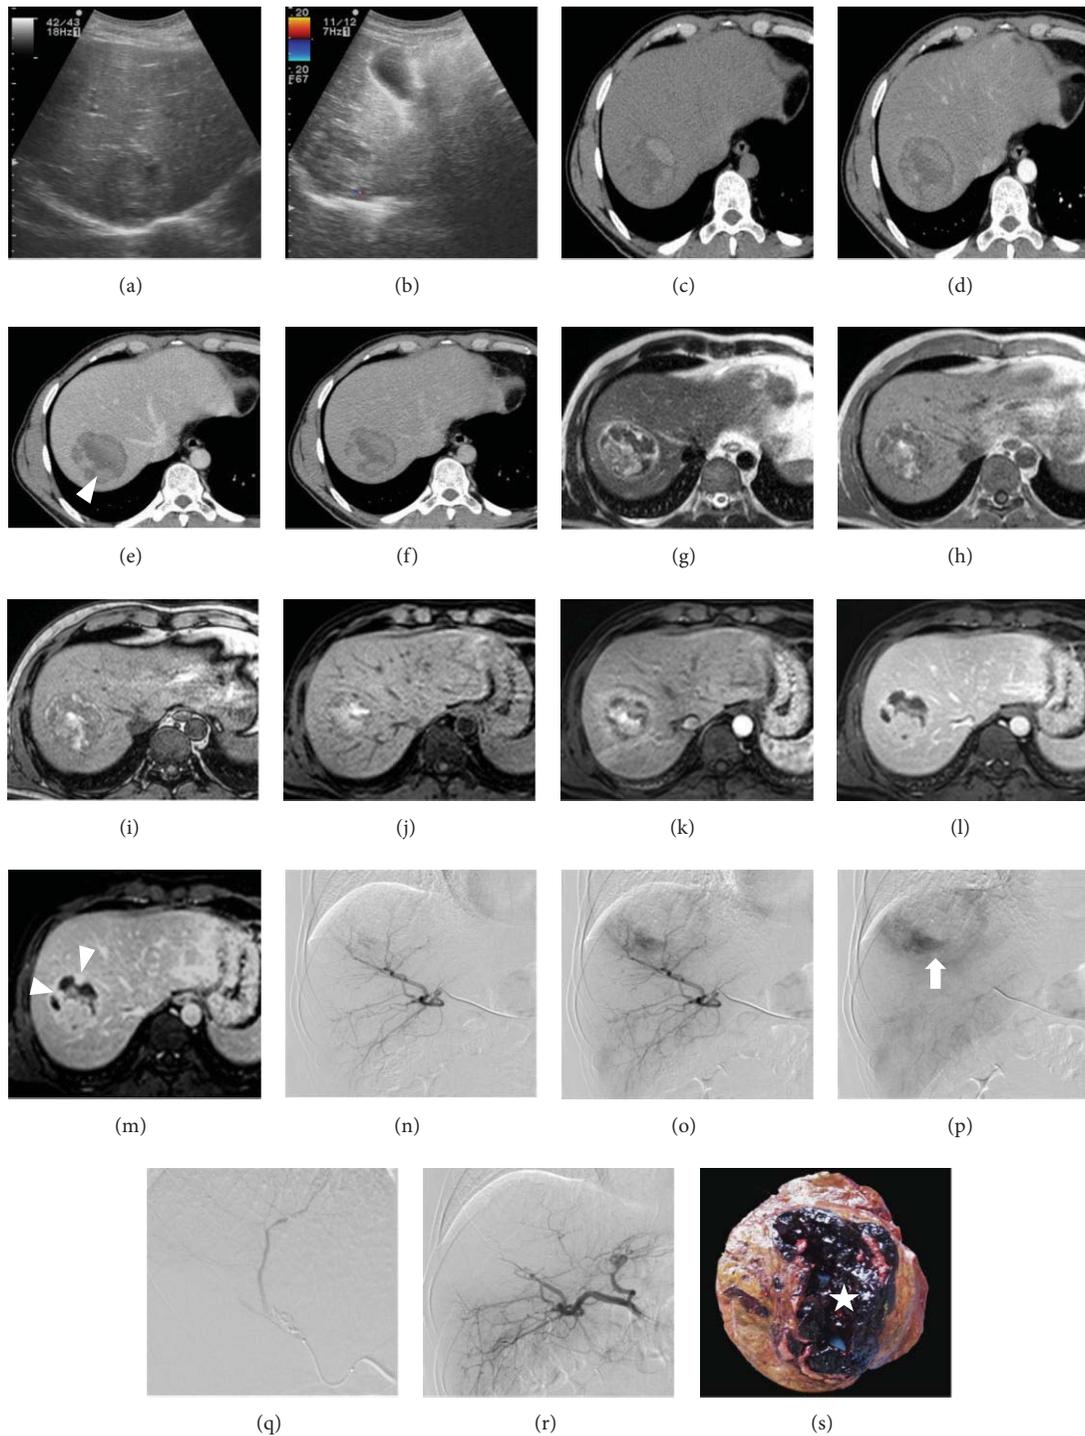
Bleeding adenoma in young man with sudden and acute upper abdominal pain. (a-b) Ultrasound, B-mode (a) and color-Doppler (b) imaging show heterogeneous lesion without significant vascularization. (c-f) CT confirms heterogeneous hyperdense bleeding mass with persistent vascularized tissue in the lower portion of the lesion (arrowheads). (g) Axial T2w image shows mixed heterogenous bleeding capsulated mass (arrows) in S VIII. (h-i) T1w in- and out-phased images confirm intralesional hemorrhage. (j-m) MR dynamic study shows vascularized tissue in the lower portion of the lesion (arrowheads). (n-p) DSA before embolization. Note hypervascular tissue in the lower part of the lesion (arrow). (q-r) DSA after embolization, complete devascularization of the nodule. (s) Cut section of the resected lesion shows large hemorrhagic component (star).
